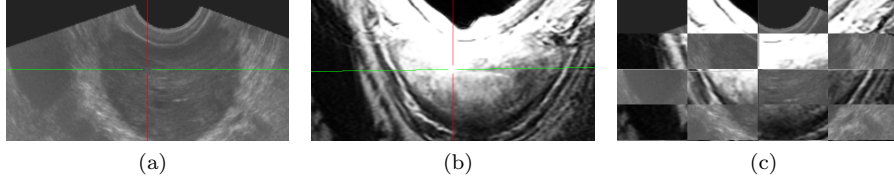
(a) Ultrasound prostate image. (b) MR prostate image. (c) Checker pattern demonstrating correct registration.
